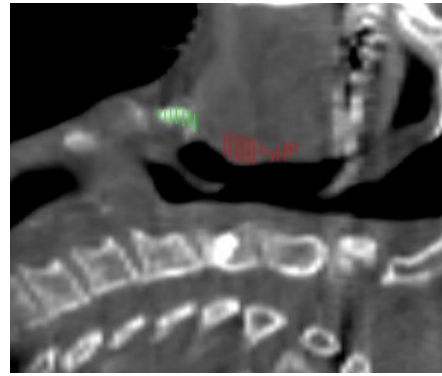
Patient B: Re-scan CT
